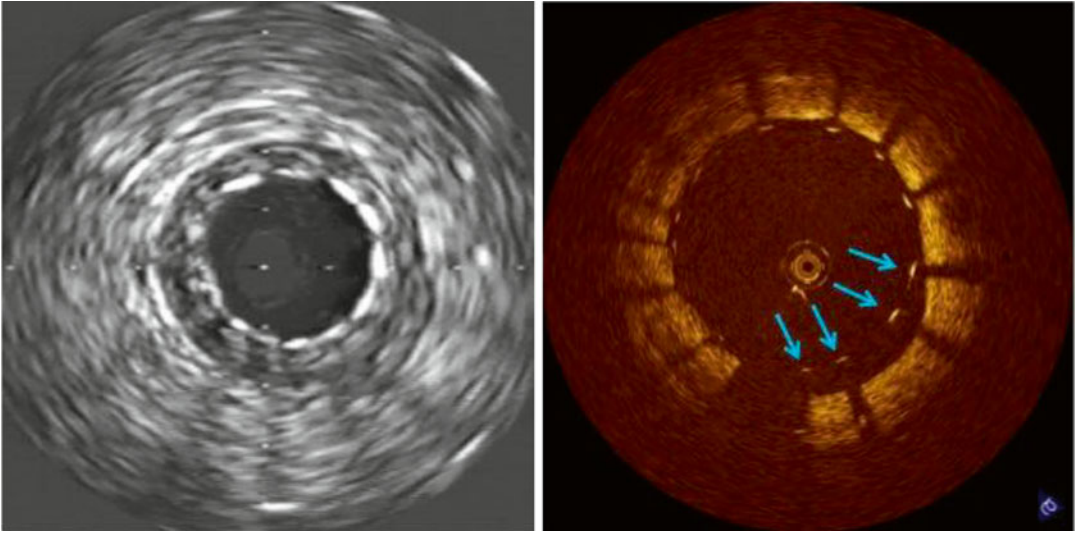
A side by side comparison of an intravascular ultrasound image and optical coherence tomographic image of an intracoronary stent showing the superior resolution at detecting stent malapposition
